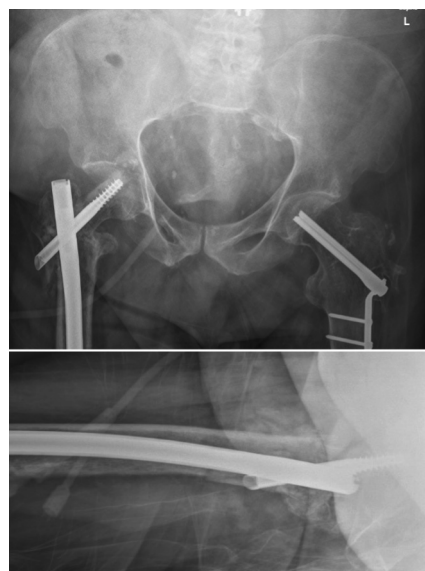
Anteroposterior and lateral radiographs at 6 weeks postoperative.
